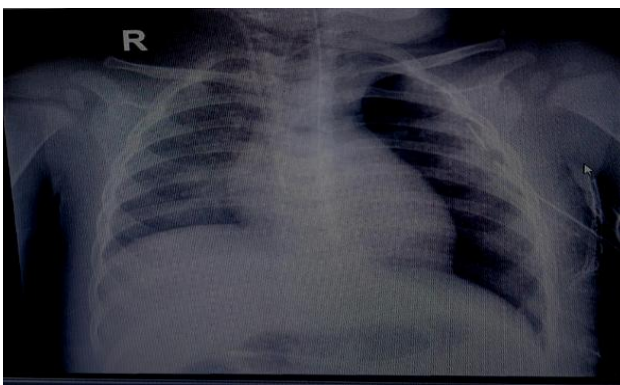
Post-operative chest X-ray showing left lung expansion with ICD in situ.
